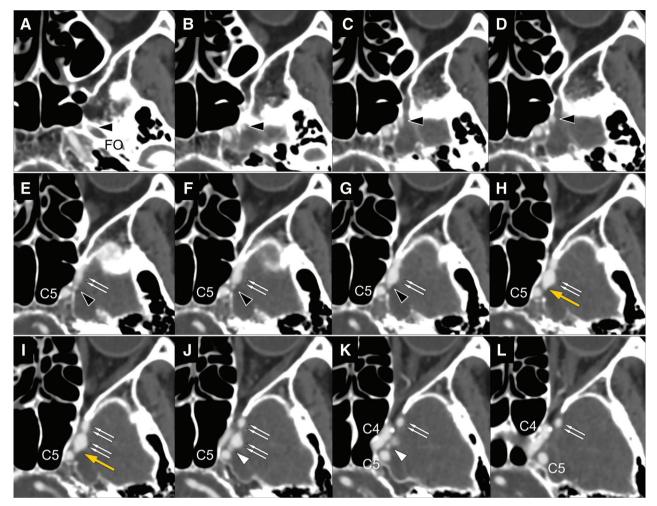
(A-L) On the preoperative 3D-CTA axial source image, the left AMA (black arrowhead: proximal side, white arrowhead: distal side) formed a direct shunt with the superficial middle cerebral vein (double white arrow) in the yellow arrow region after passing through
